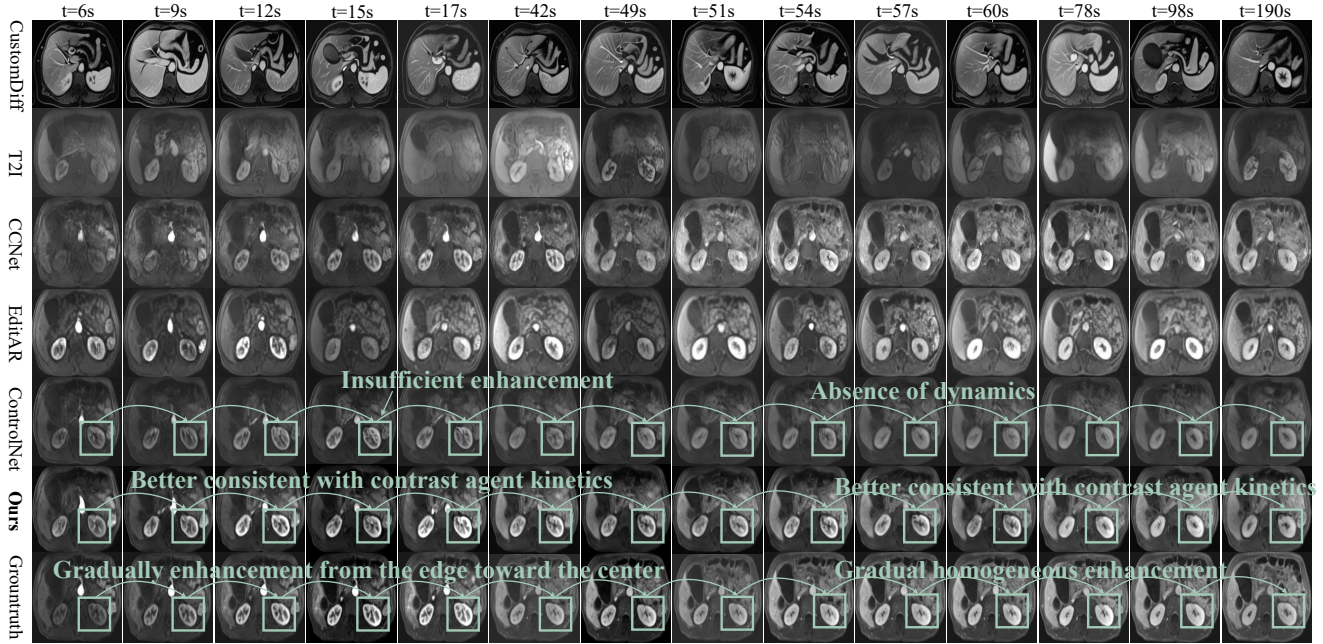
Visualization results of kidney in Abdominal DCE-MRI shows that our CEKWorld reproduces the typical renal perfusion pattern of cortical edge enhancement first, gradual diffusion to the medulla until homogeneity, while methods such as T2I and CCNet have problems of abnormal enhancement or blurred structure, and ControlNet lacks dynamics in the delay phase.
